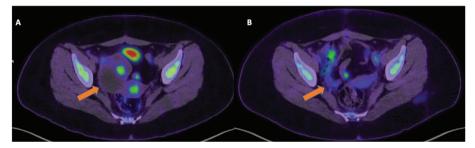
Restaging. FDG PET/CT images obtained from a 19-yr-old patient with atypical serous ovarian carcinoma referred for restaging following a unilateral oophorectomy and a cystectomy. Image A demonstrates a right-sided malignant ovarian tumor with focal areas of increased FDG accumulation on pre-treatment FDG PET/CT, which demonstrates significant post-treatment improvement in Image B.
